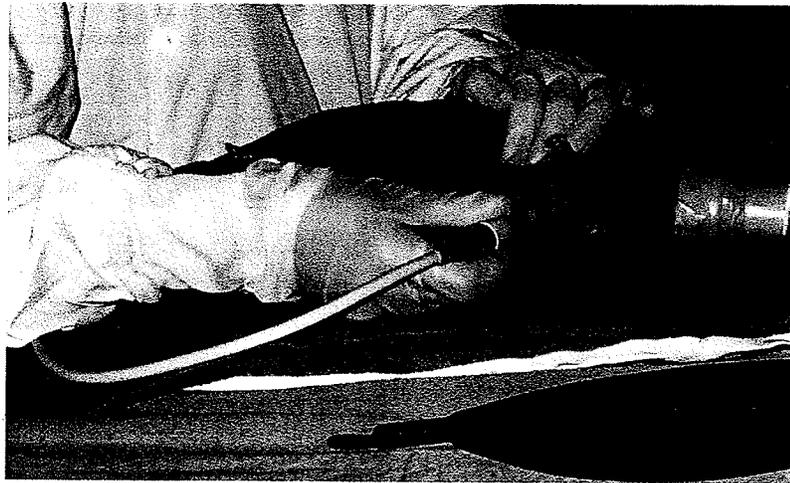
Image Acquisition by Echocardiography.
